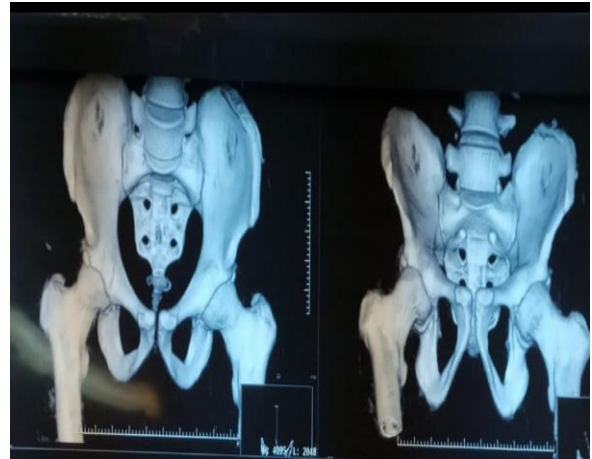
Computed tomography ruled out the existence of associated lesions and/or intra-articular fragments
